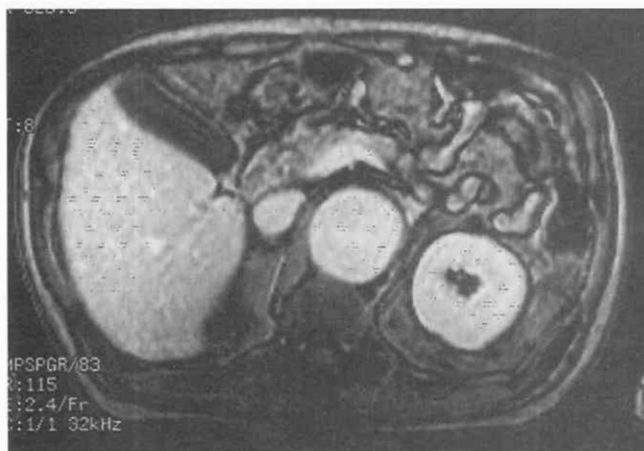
Supraceliac abdominal aortic aneurysm, as seen on a fat-suppressed, limited flip-angle MR image. There is no thrombus in this aneurysm.
